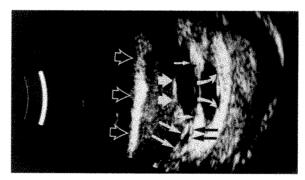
(Whitacre). Reflection of the anterior segment of a phakic eye with a 60% gas-fill of the vitreous cavity. The patient's face was in a prone position and the ultrasound probe was in line with the visual axis. The large hollow arrows point to the gas-fluid meniscus. The mirror-image reflections of the lens (large solid arrows), iris (small arrows), and cornea (curved arrows) were clearly seen, as were the cyclitic membranes bridging the space between the iris, lens, and ciliary body (medium white arrows and black arrows).
